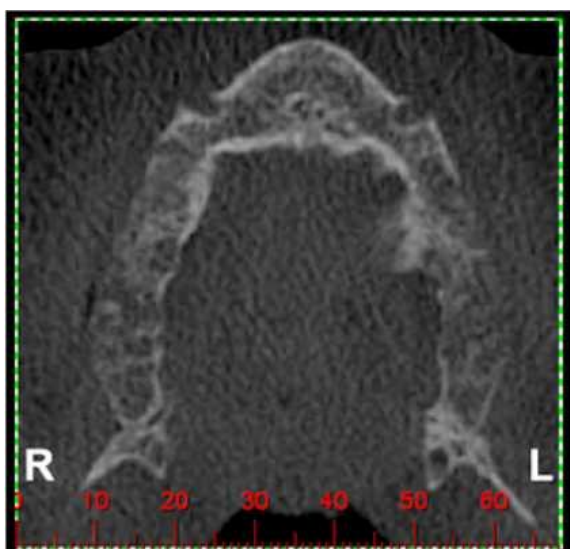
Axial CBCT section showing the trifid nasopalatine canal consisting of independent canals separated by bony septa.
